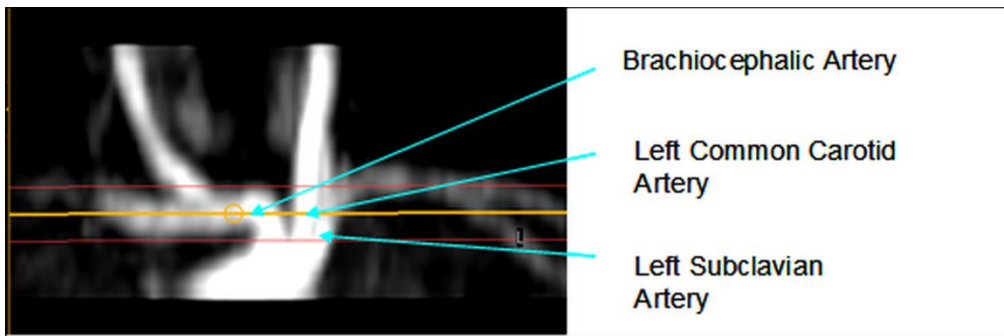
Brachiocephalic, left common carotid and left subclavian arteries: Angiogram of the brachiocephalic, left common carotid and left subclavian arteries in a preterm infant. Yellow (centre) and red (edge) lines show the placement of a 4mm thick PC MRI sequence. Topology of these vessels meant that flow could not be quantified accurately in all 3 vessels using just 1 sequence.
